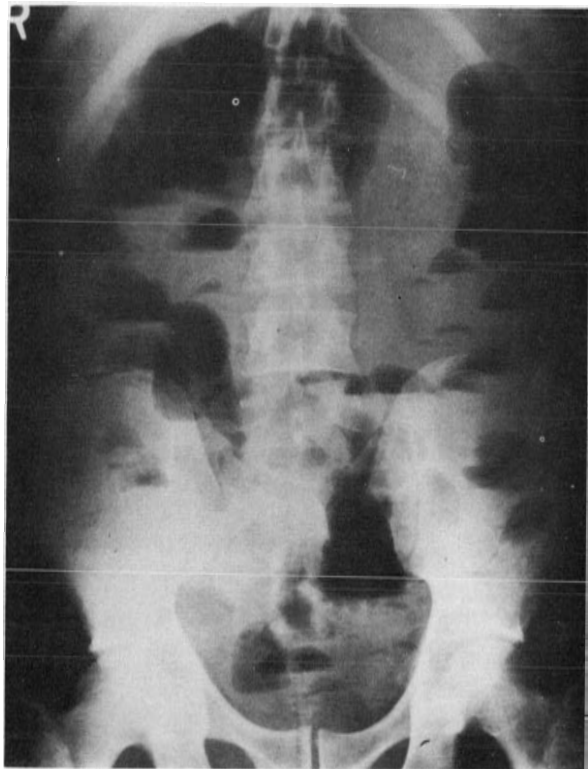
(Case 2.) Plain X-ray of abdomen shows fluid level and gas in both small and large bowels. Serum electrolytes were normal. (29 March 1971.)
